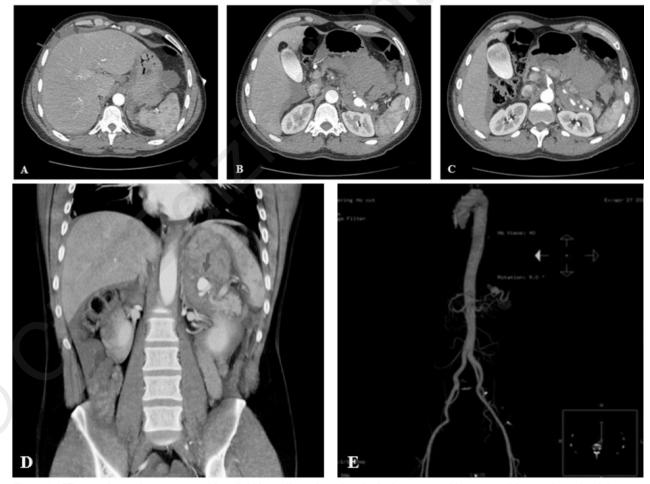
CT-scan shows the presence of free fluid in perihepatic and perisplenic space and hepatorenal fossa, along the right paracolic gutter, in the omental bag and in pelvis (A). CT-scan shows also a pathological enlargement of the distal tract of the splenic artery (B, D, E) and the presence of a thrombus in the celiac artery (C).
